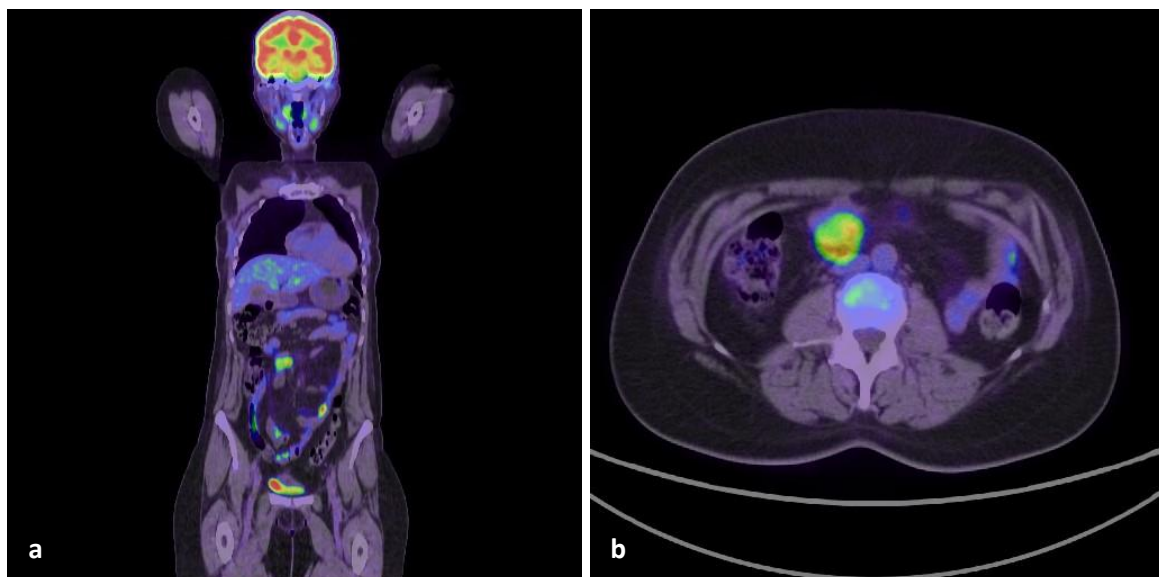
FDG-PET-CT: (a) coronal section, active areas on the intestinal anseae (max SUV= 9.7); (b) axial section, active area on the lower quadrant (max SUV= 9.7).
